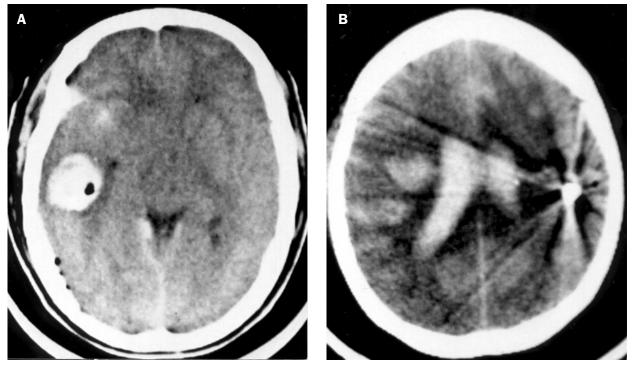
A computed tomography scan showing: (A) single-lobe gunshot injury; (B) cross-mid-sagittal, multilobar injury.
